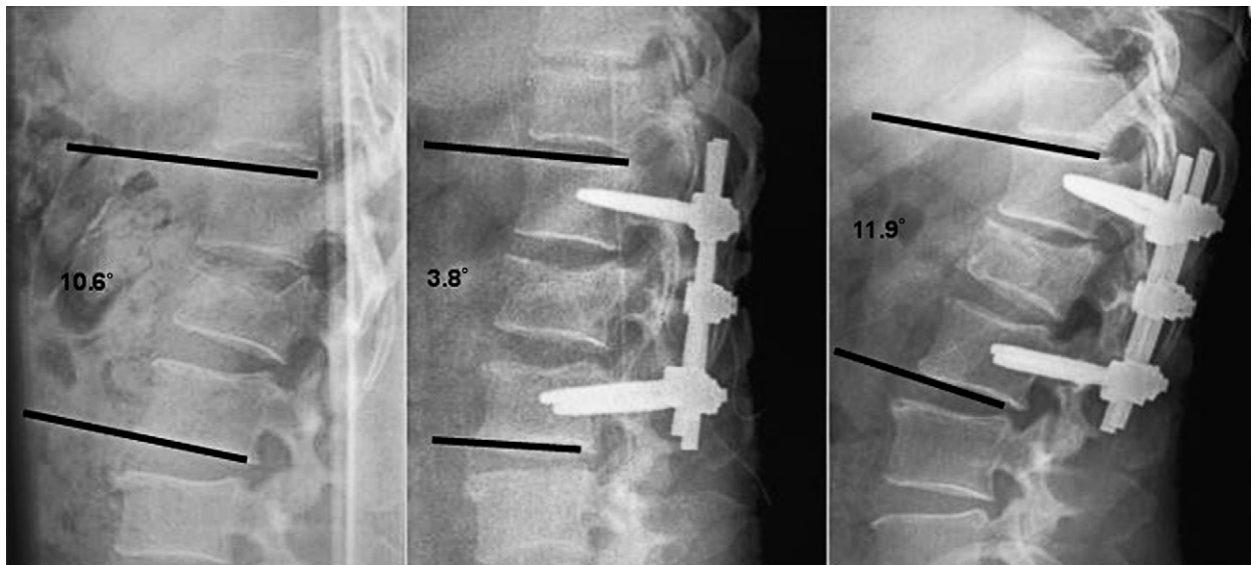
Lateral radiographs taken at (Left) injury, (Center) immediately after surgery, and (Right) at final follow-up (3 years) showing recurrence of kyphosis.
